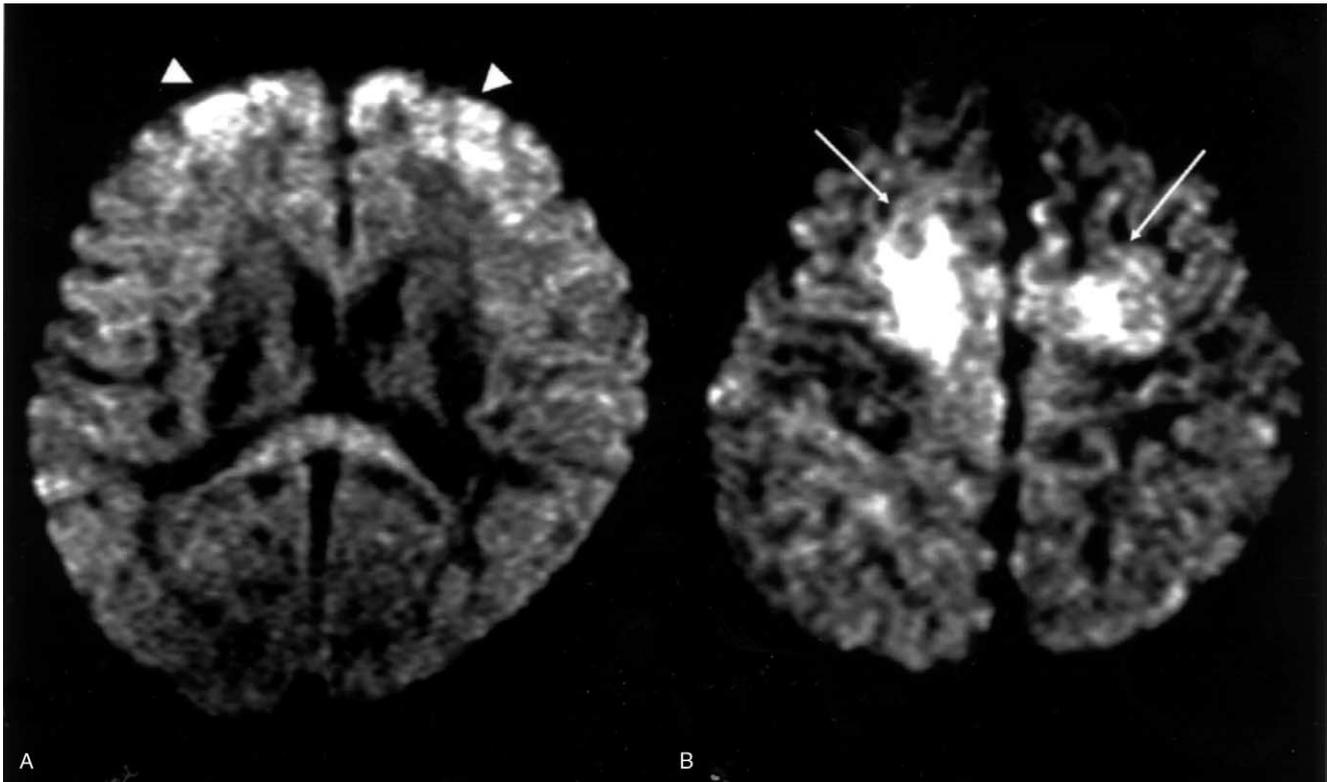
Diffusion-weighted magnetic resonance imaging (TR/TE = 3300 ms/123 ms, $b = 1000 \text{ s/mm}^2$). (A) High signal intensity (arrowheads) in the cortex of both frontal lobes at the sixth day from onset in Patient 5. (B) High signal intensity (arrows) in the cortex and white matter of both frontal lobes at the sixth day from onset in Patient 9.
